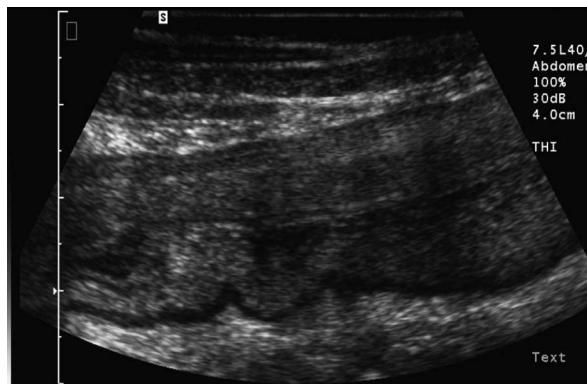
Sonographic appearance of an inflamed colon segment in Crohn's disease. Characteristic appearance: thickened wall diameter (almost 1 cm), partial loss of wall stratification, prominent submucosal layer, narrowed lumen and mesenteric fat hypertrophy.
